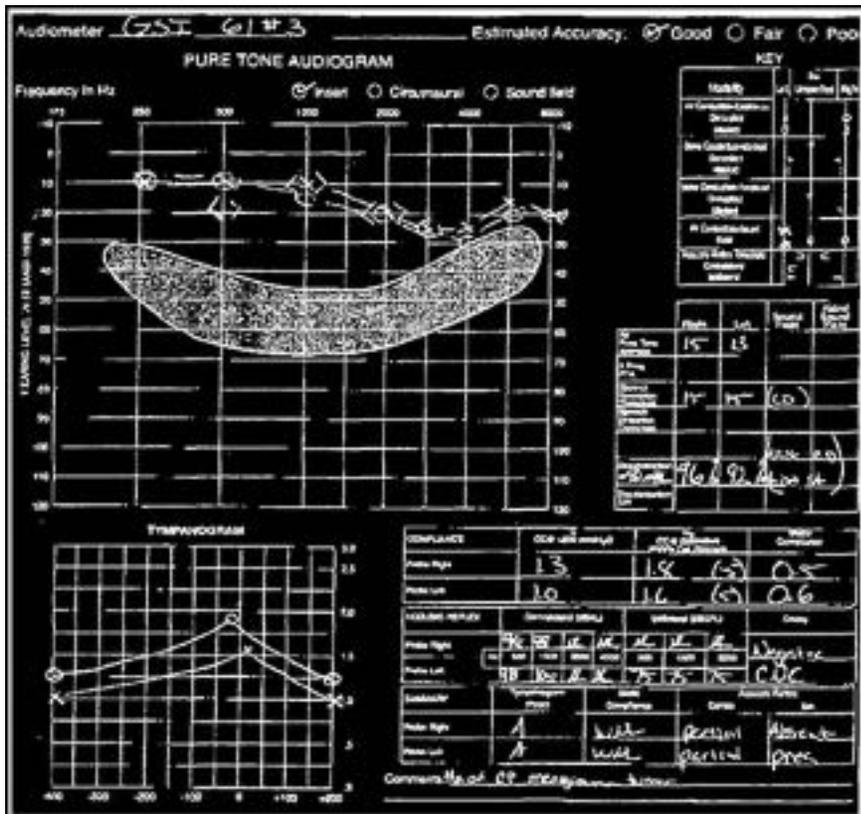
Meningioma presenting with hemifacial spasm. (A) Audiogram showing very mild sensorineural hearing loss at 3 and 4 kHz in both ears. The speech discrimination scores are 96% for the right ear and 92% for the left ear. (B) Coronal postcontrast T1 magnetic resonance imaging through the internal auditory canal (IAC) showing meningioma involving the right IAC and jugular foramen.
